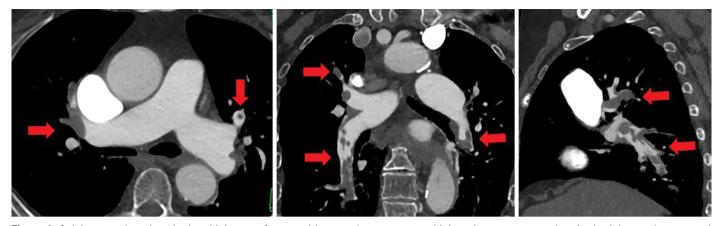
Axial, coronal, and sagittal multiplanar reformatted images demonstrate multiple pulmonary artery clots in the lobar and segmental pulmonary arteries (arrows) from two different patients with pulmonary thromboembolism. Axial computed tomography pulmonary angiography images show samples of point scales 1 (<50% pulmonary artery (PA) obstruction), 2 (50%–99% PA obstruction), and 3 (total obstruction) in left and right interlobar arteries (circles)
